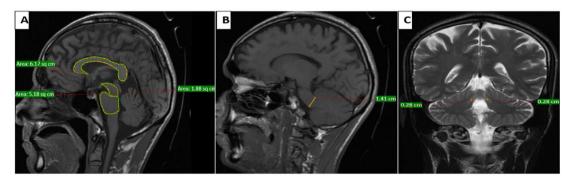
Sagittal T1-weighted MRI image of normal controls showing the measurement of (A) corpus callosum area (6.17 cm²), midbrain area (1.88 cm²), pons area (5.18 cm²), (B) MCP width (1.41 cm), (C) coronal T2-weighted MRI image of normal controls showing the measurement of right SCP width (0.28 cm) and left SCP width (0.28 cm).
